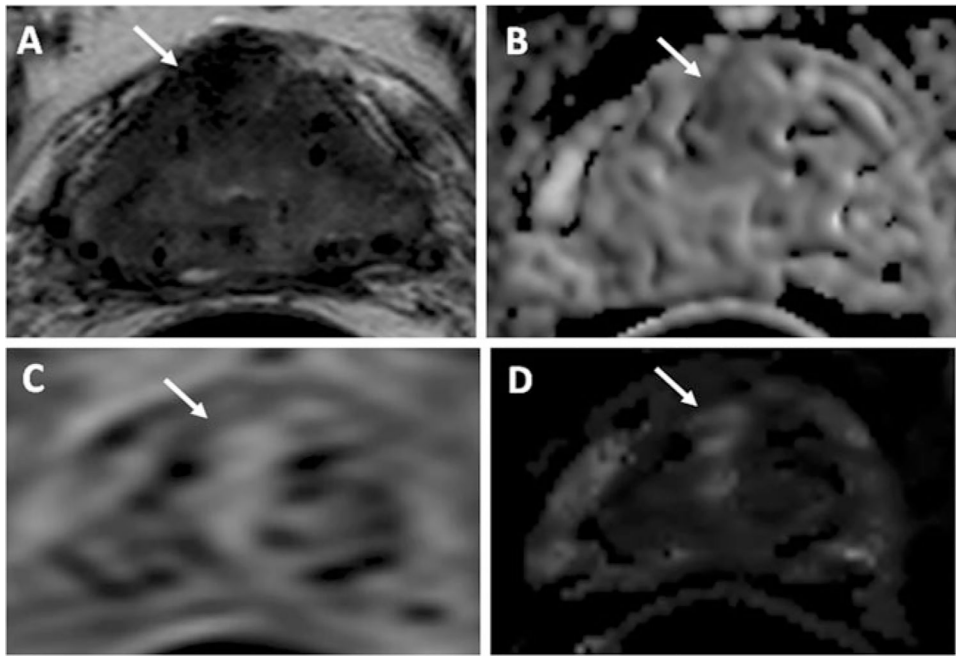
A 63-year-old man with a serum PSA of 1.93 ng/dl 6 years after brachytherapy. Axial T2-W MR image (a), ADC map of DW MRI (b), raw DCE MR image (c), and k_{ep} map derived from DCE MRI (d) demonstrate a recurrent lesion in the right anterior central gland (*arrow*). Subsequent transrectal ultrasonography/MRI fusion-guided biopsy revealed it to be a Gleason 3+3 (80 %) tumor
